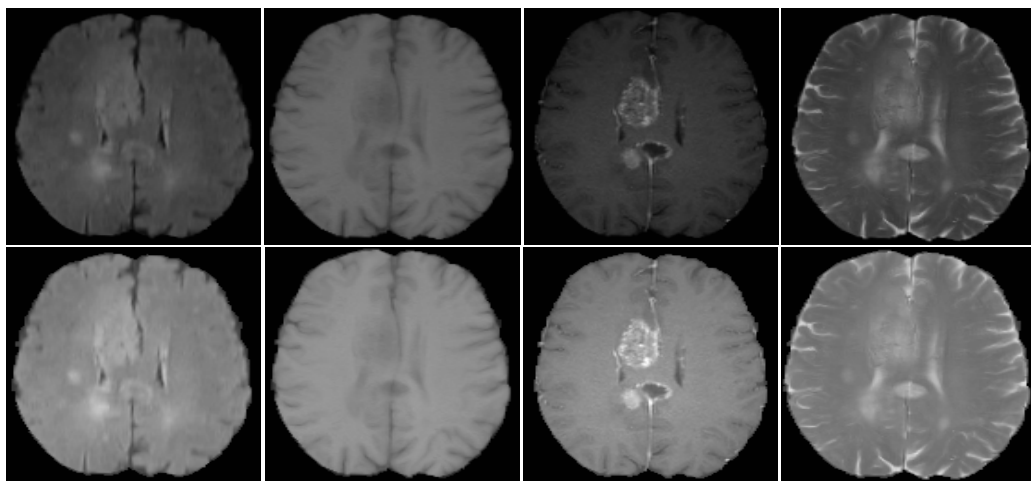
A case for intensity normalization. Top row: original images. Bottom row: normalized images. From left to right: T2-FLAIR, T1, T1ce, and T2 image.
